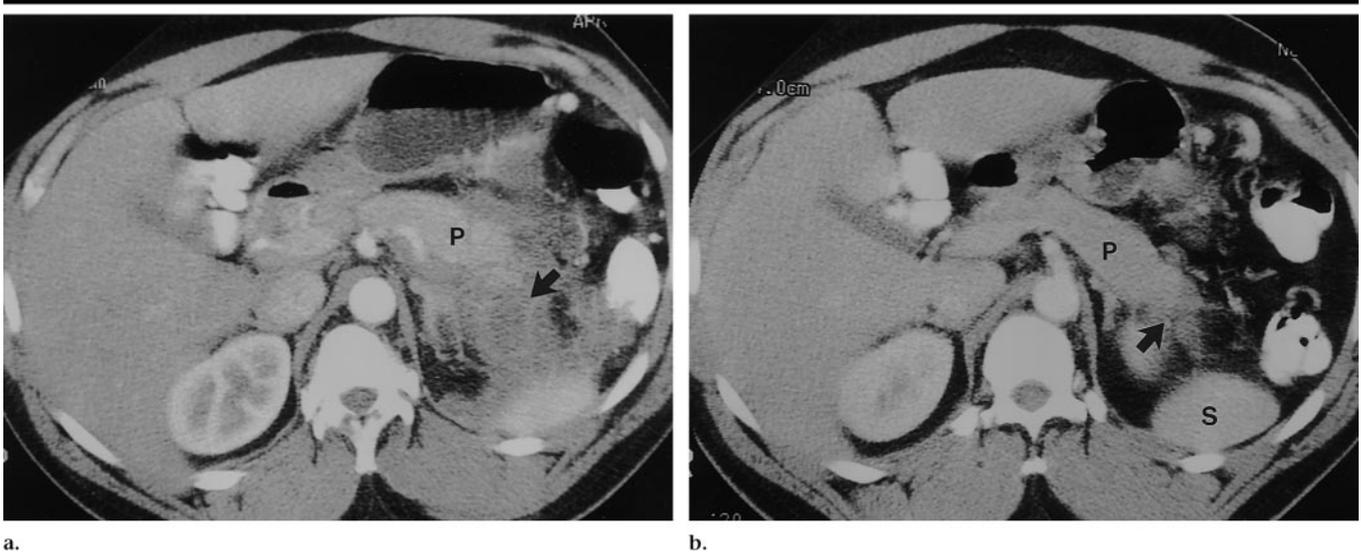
Alcoholism-related pancreatitis in a 32-year-old man with necrosis of the tail of the pancreas. *P* = pancreas. (a) Initial transverse CT scan obtained with intravenous and oral contrast material shows fluid collections (arrow) adjacent to the body and tail of the pancreas. There is lack of enhancement of the tail of the pancreas. (b) Follow-up transverse CT scan obtained 6 months later reveals scarring with atrophy of the tail of the pancreas (arrow). *S* = spleen.
